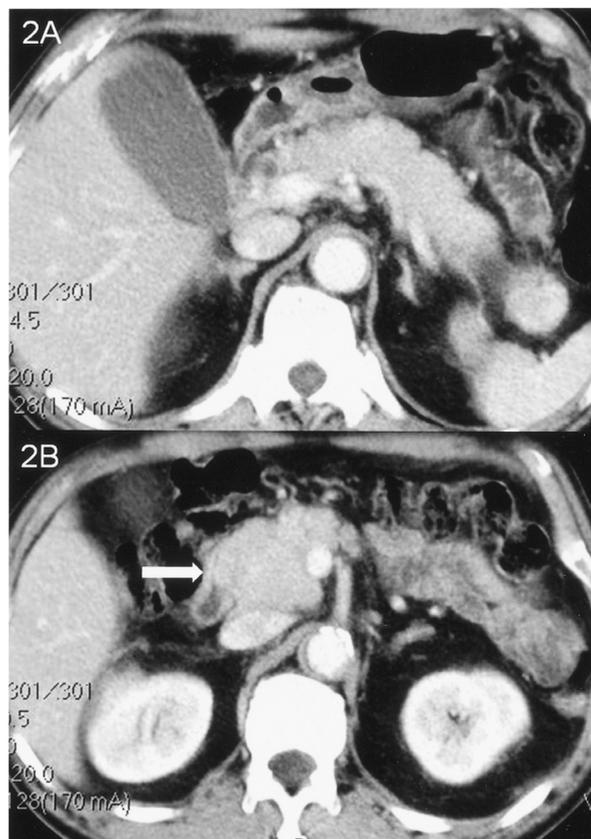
Abdominal computed tomography revealed diffuse but uniformly enhanced pancreatic enlargement (2A), especially in the pancreatic head (2B, arrow).
